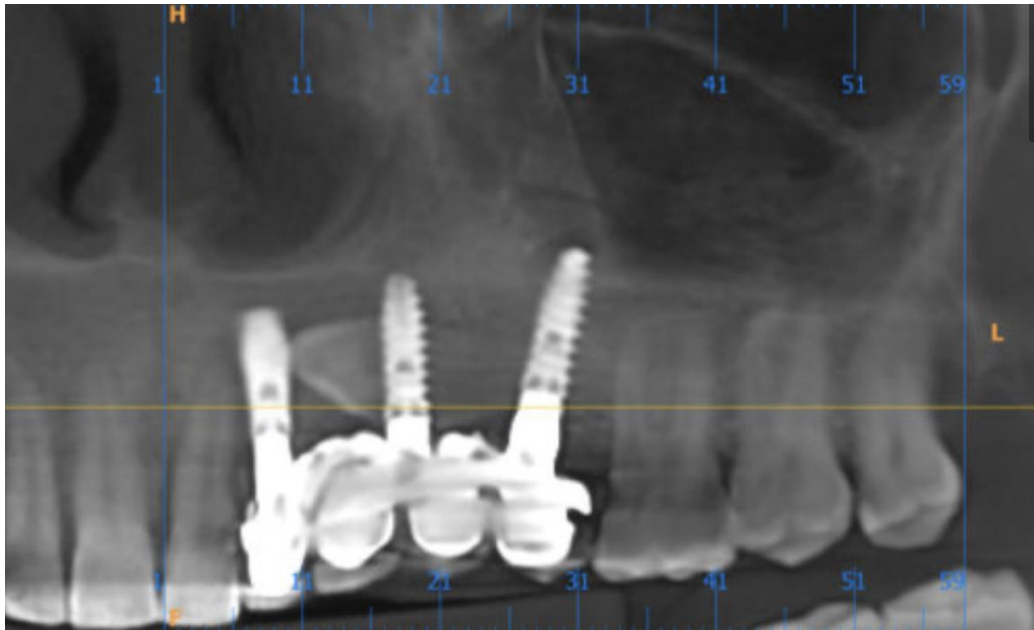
postoperative CBCT image after prosthesis placement
